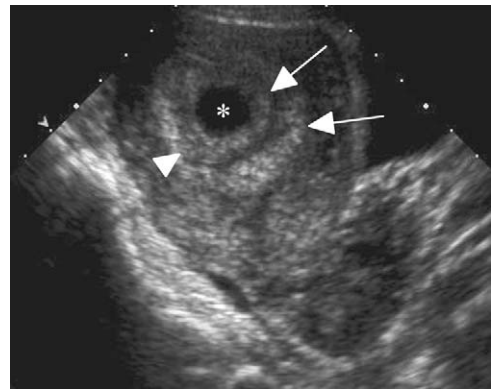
Double decidual sac sign. Transabdominal ultrasound of the uterus with an intrauterine gestational sac (*) shows a double layer of echogenic decidua (arrows) separated by the hypoechoic endometrial cavity (arrowhead).
